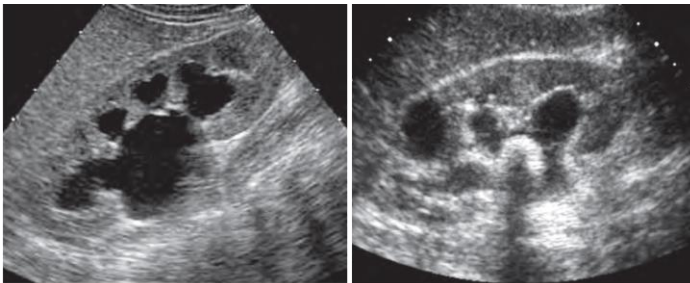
Ultrasonography of kidney: a - enlargement pyelo-calyceal system with obstruction of the ureter; b - stones of the renal pelvis, that led to dilation of pyelo-calyceal system
